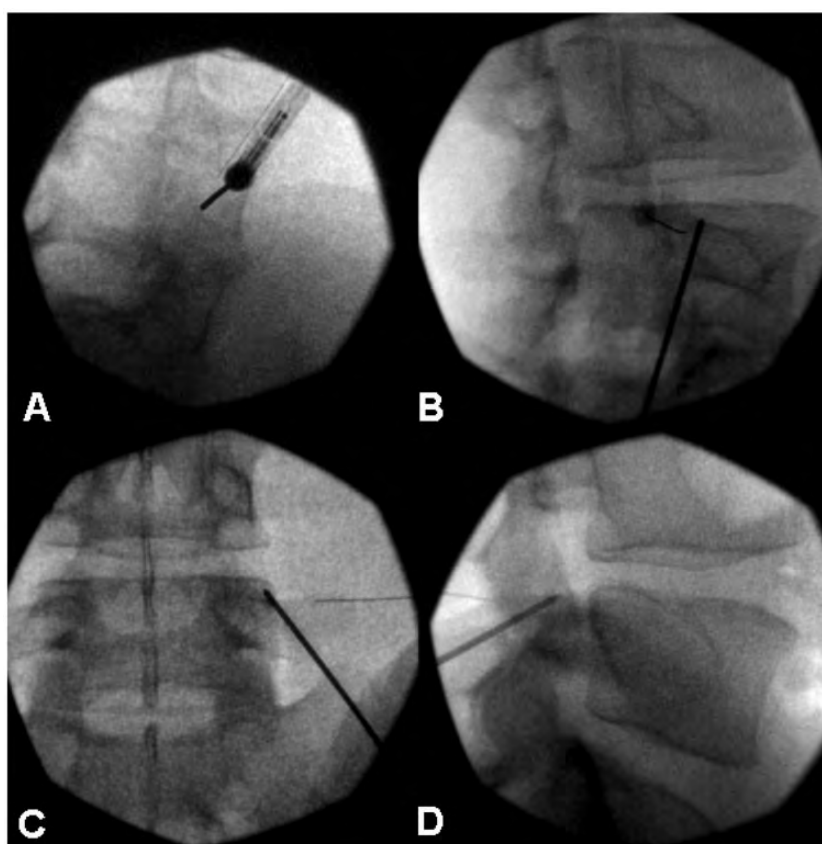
Radiographs of an electrode in place against an L4 medial branch, taken during an actual procedure. A) Declined view, showing an electrode against the neck of the superior articular process of L5. B) Oblique view, showing the electrode crossing the junction of the superior articular process and transverse process. C) Antero-posterior view, showing the electrode placed obliquely against the superior articular process. D) Lateral view, showing how the electrode crosses the neck of the superior articular process.
